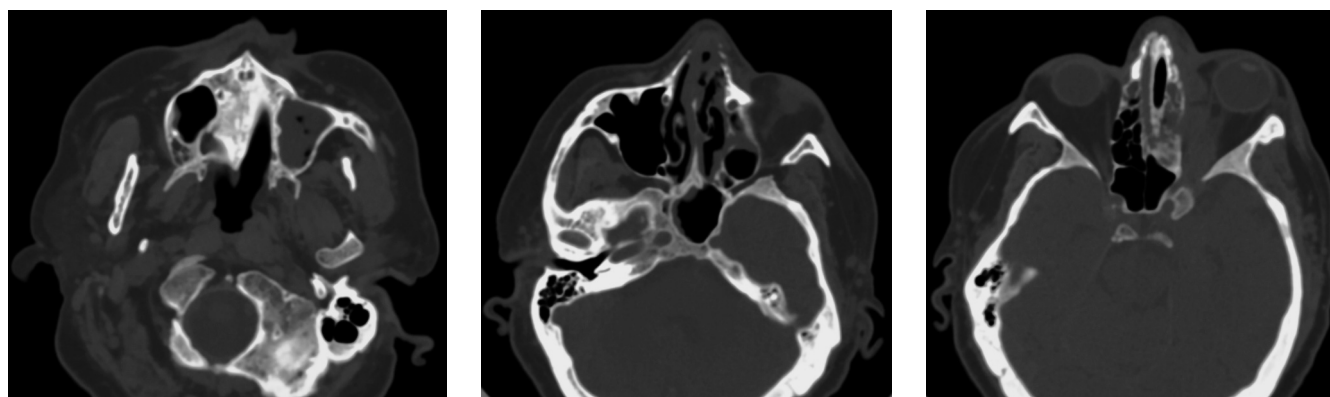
MRI of the paranasal sinuses dated April 29, 2022. Inflammatory changes in the paranasal sinuses are most pronounced in the maxillary sinus on the left, with probable destruction of the medial wall of the orbit and lesion of the adjacent cells of the ethmoid labyrinth, spreading to the area of the superior orbital fissure, left cavernous sinus
